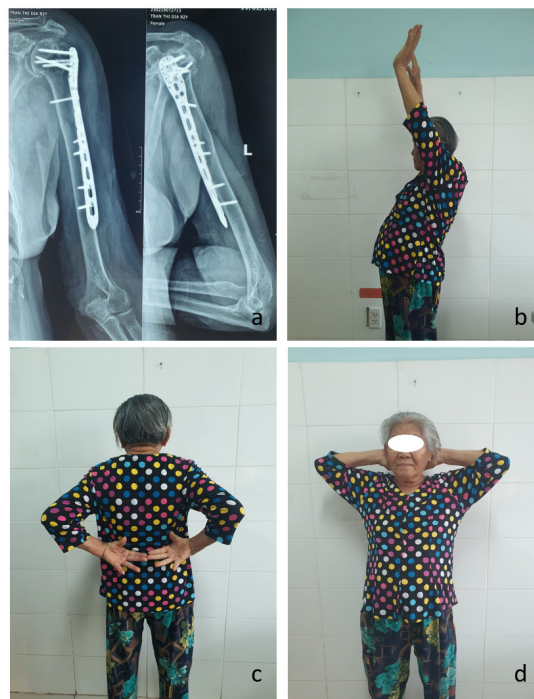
(a) X-ray in 33 months of follow-up showed good fracture healing without osteonecrosis of the humeral head. (b)(c)(d) The patient had good function of the left arm compared to the right eventually.
